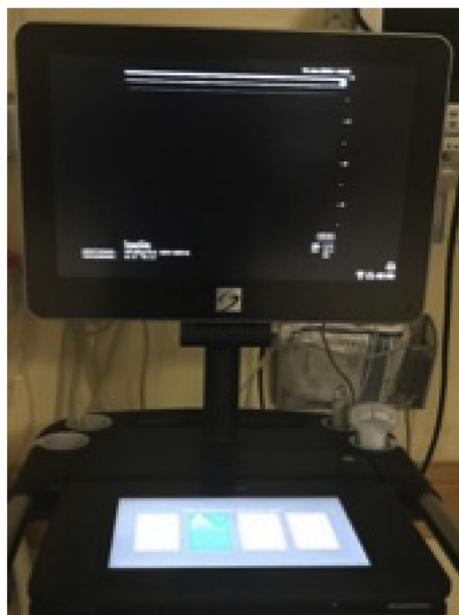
Ultrasound machine.
